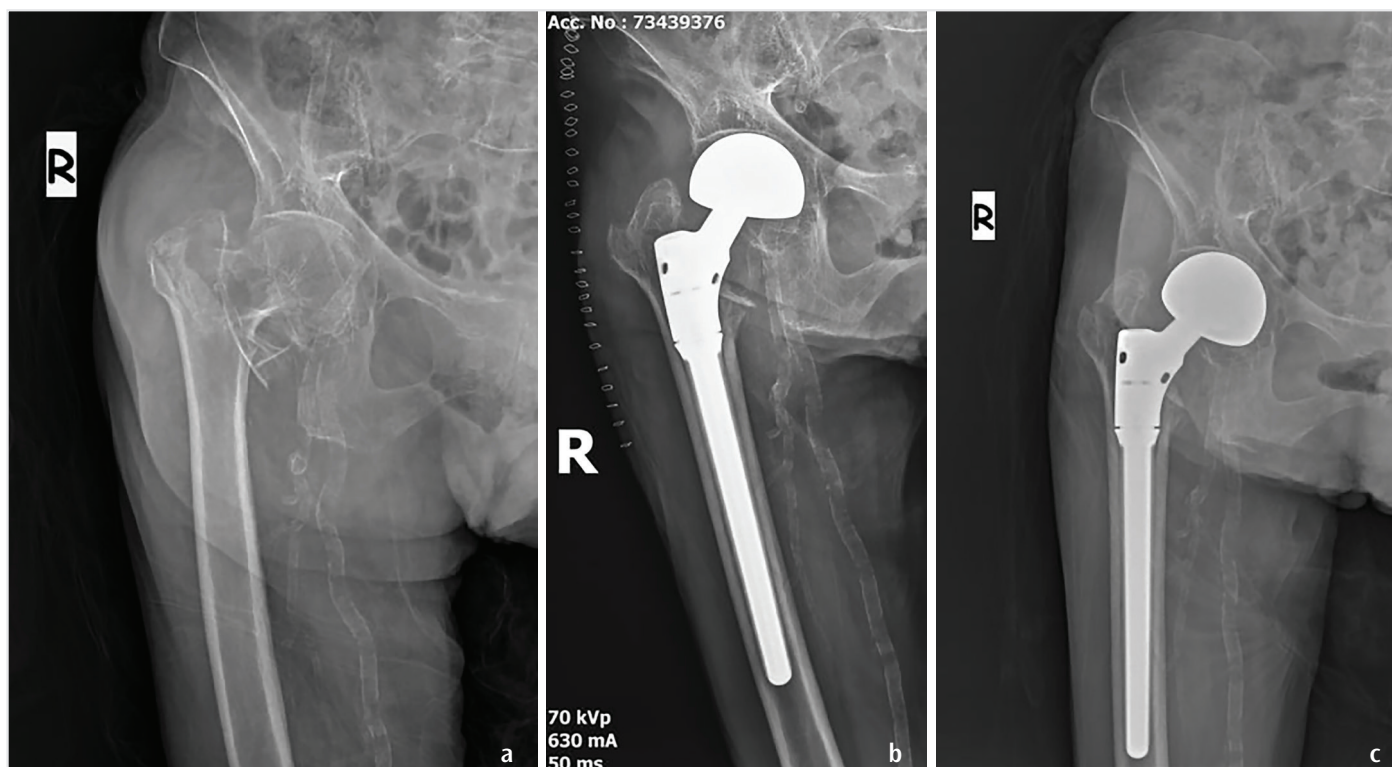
An 82-year-old female patient with an unstable intertrochanteric fracture of the right hip. Preoperative anteroposterior radiograph a), immediate postoperative radiograph following cementless hemiarthroplasty using a distally fixed modular stem b), and radiograph at 1-year postoperative follow-up. Consent of the patient is taken
